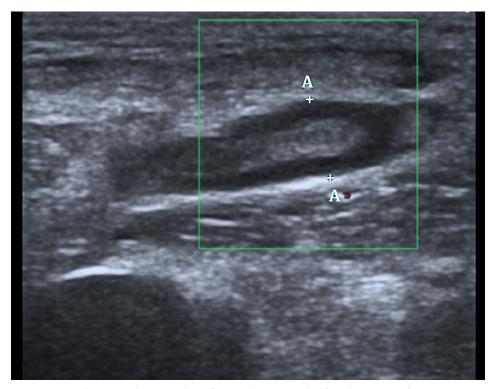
Follow-up ultrasound performed one month after the onset of symptoms showing cecal appendix with thickening of the appendix wall and contained within the hernia sac.
